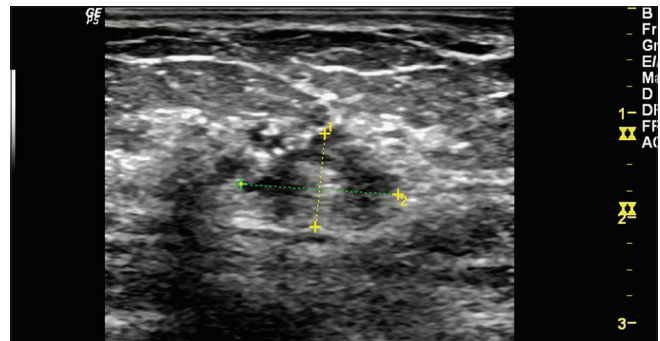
Ultrasound of the left breast showing an ill-defined heterogeneously hypoechoic lesion at 10 o'clock position in the left breast suggestive of suspicious morphology.
